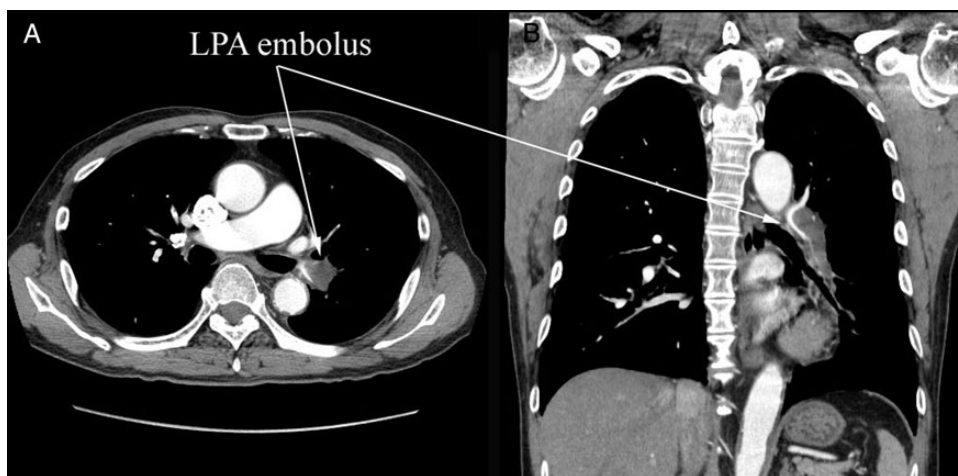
Preoperative CT. (A) Cross section and (B) coronary section. A large embolus stuck into the left pulmonary artery (LPA). The embolus formed acute angles with the vessel wall, which suggested an acute pulmonary embolism.
